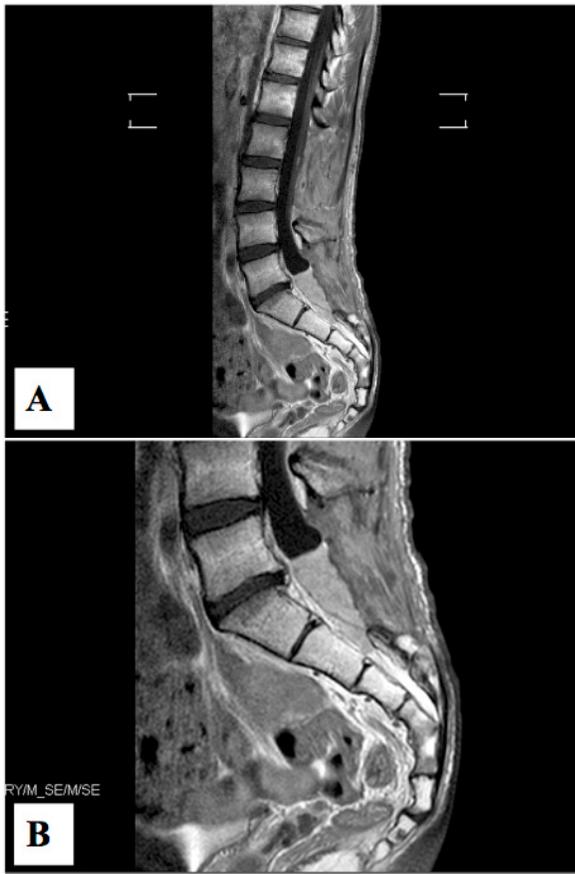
Preoperative MRI. Sagittal T1-weighted gadolinium-enhanced (A) and T2-weighted (B) magnetic resonance imaging demonstrating two enhancing intradural lesions. One extending from L5 to S2 and other smaller lesion at L2-L3 level.
